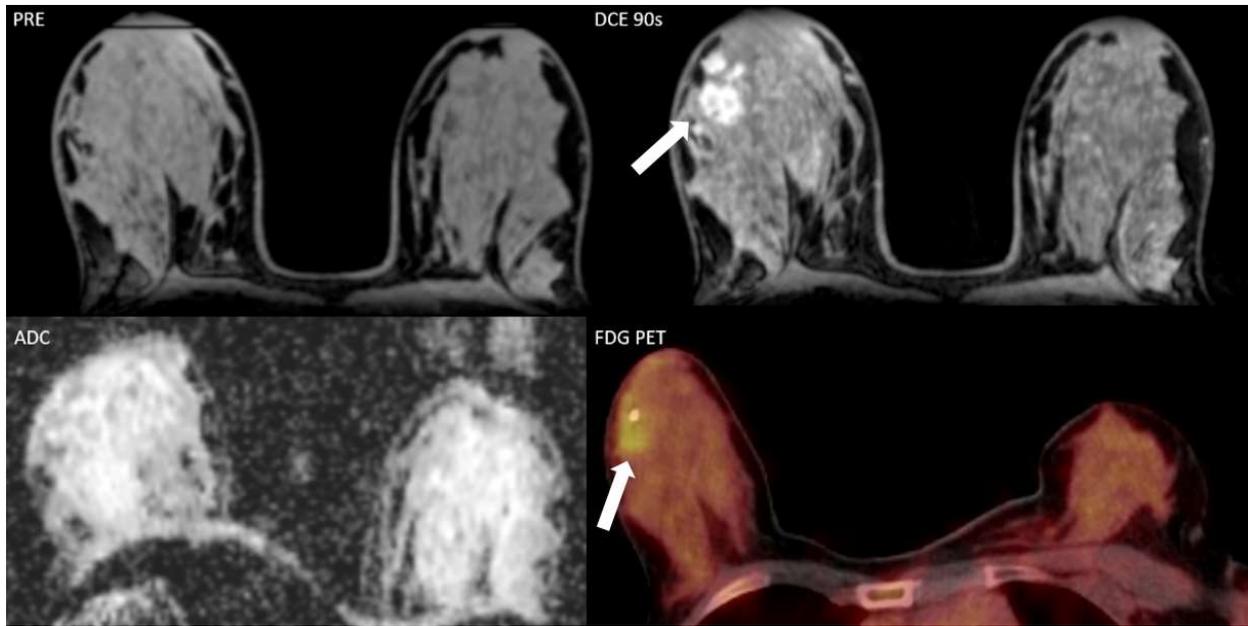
Mucinous carcinoma in the right breast in a 42-year-old premenopausal woman. Pre-contrast fat-saturated T1-weighted MR images (a) show an extreme amount of fibroglandular tissue (ACR d), whereas BPE in DCE-MRI (b) is mild. On DWI (c), ADC values of normal breast parenchyma are $2.17 \times 10^{-3} \text{ mm}^2/\text{s}$, while SUVmax (BPU) in ^{18}F -FDG-PET/CT (d) is 2.58.
